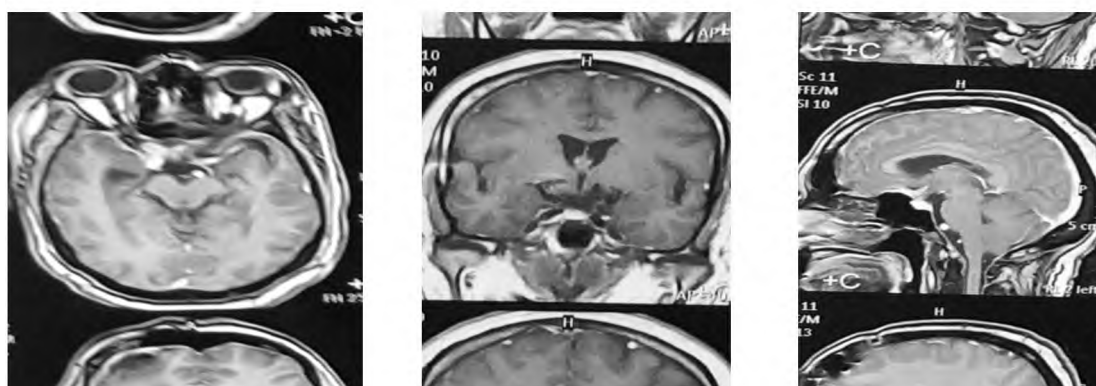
Post operative MRI with contrast.
